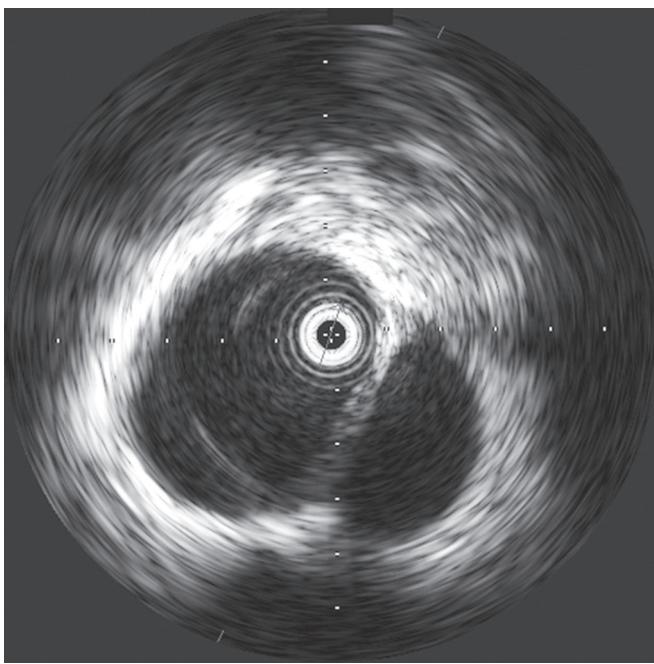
Intravascular ultrasound image of a patient with blunt thoracic aortic injury demonstrates a pseudoaneurysm.
